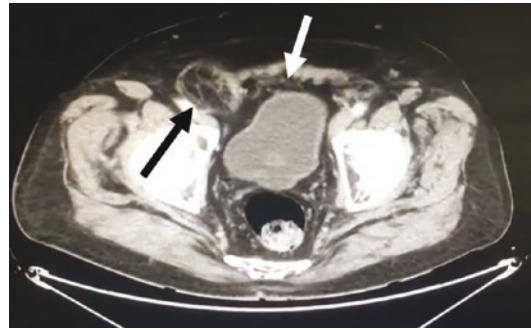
CT scan obtained within 2 months after right inguinal hernia repair with mesh. An obvious fat-containing recurrence (black arrow) is observed. The mesh can be noted within the space of Retzius (white arrow)
